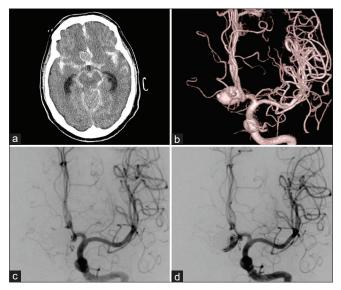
(a and b) Initial computed tomography (CT) shows severe subarachnoid hemorrhage with a mass lesion in the interhemispheric fissure, and CT angiography shows a large ruptured cerebral aneurysm in the anterior communicating artery. (c) Postoperative cerebral angiography reveals that endovascular treatment achieved adequate coiling with a small neck remnant. (d) Follow-up cerebral angiography 27 months after initial treatment shows recurrence of aneurysm and enlargement of neck remnant.
